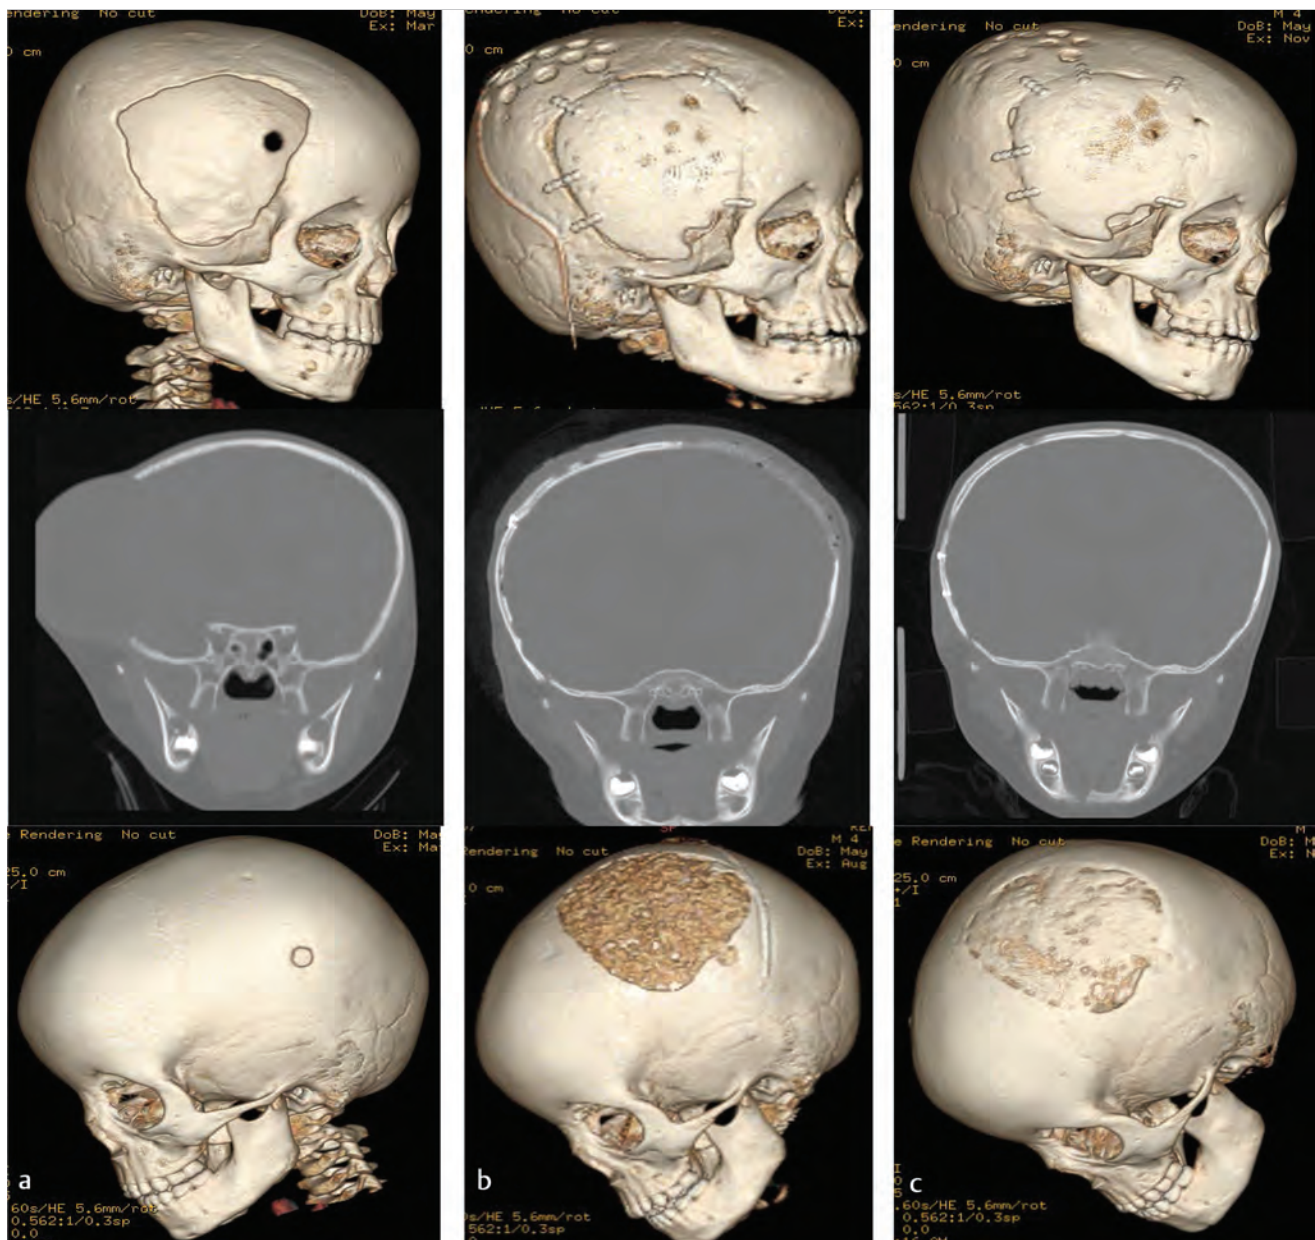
A 4-year-old child with a large cranial defect following a motor vehicle accident. (a) Appearance before undergoing exchange cranioplasty. (b) Immediate postoperative CT images to rule out hydrocephalus and dural injury show full-thickness parietal graft over original defect and particulate graft in the parietal donor site. (c) Healed grafts 3 months postoperatively.
